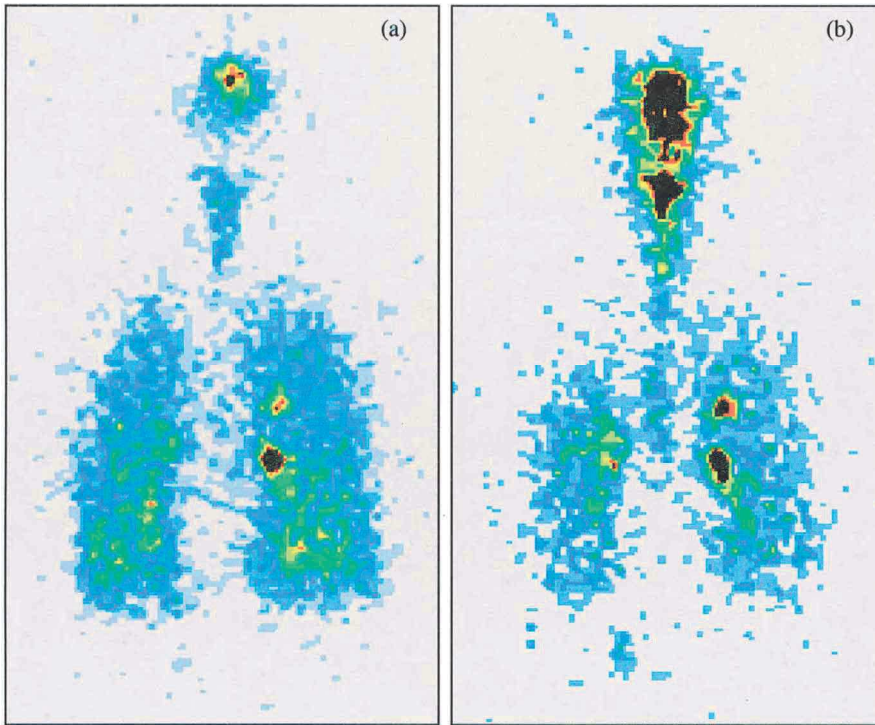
Deposition of 3 (a) and 5 (b) μm porous particles in healthy subjects obtained via scintigraphy method (Dunbar et al., 2002)
